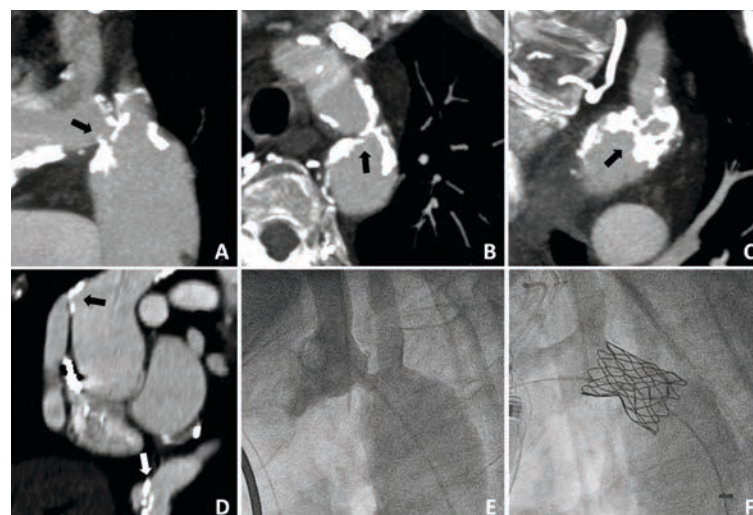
Pre- and post-procedural imaging in Patient 2. Pre-procedural multiplanar reformatted CTA images in the (A) sagittal, (B) axial, and (C) coronal projections demonstrate a heavily calcified native aortic coarctation (black arrows). (D) A separate coronal view reveals severe calcified stenoses of the proximal (black arrow) and distal (white arrow) ascending to descending aortic conduit. (E) Pre- and (F) post-procedural angiography reveal a significant improvement in coarctation caliber.
